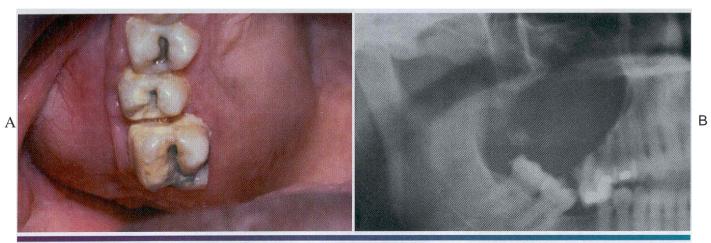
• Calcifying odontogenic cyst. A, Expansion of the posterior maxillary alveolus caused by a large calcifying odontogenic cyst. B, Panoramic radiograph of the same patient showing a large radiolucency in the posterior maxilla. A small calcified structure is seen in the lower portion of the cyst. (Courte sy of Dr. Tom Brock.)
